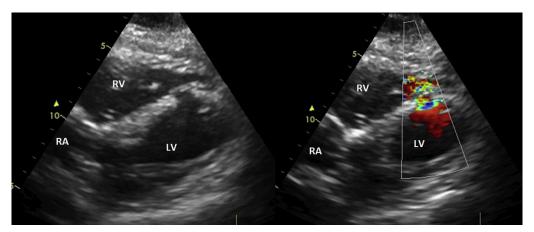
Echocardiography showing post-MI apical muscular ventricular septal defect. LV, Left ventricle; RA, right atrium; RV, right ventricle.
